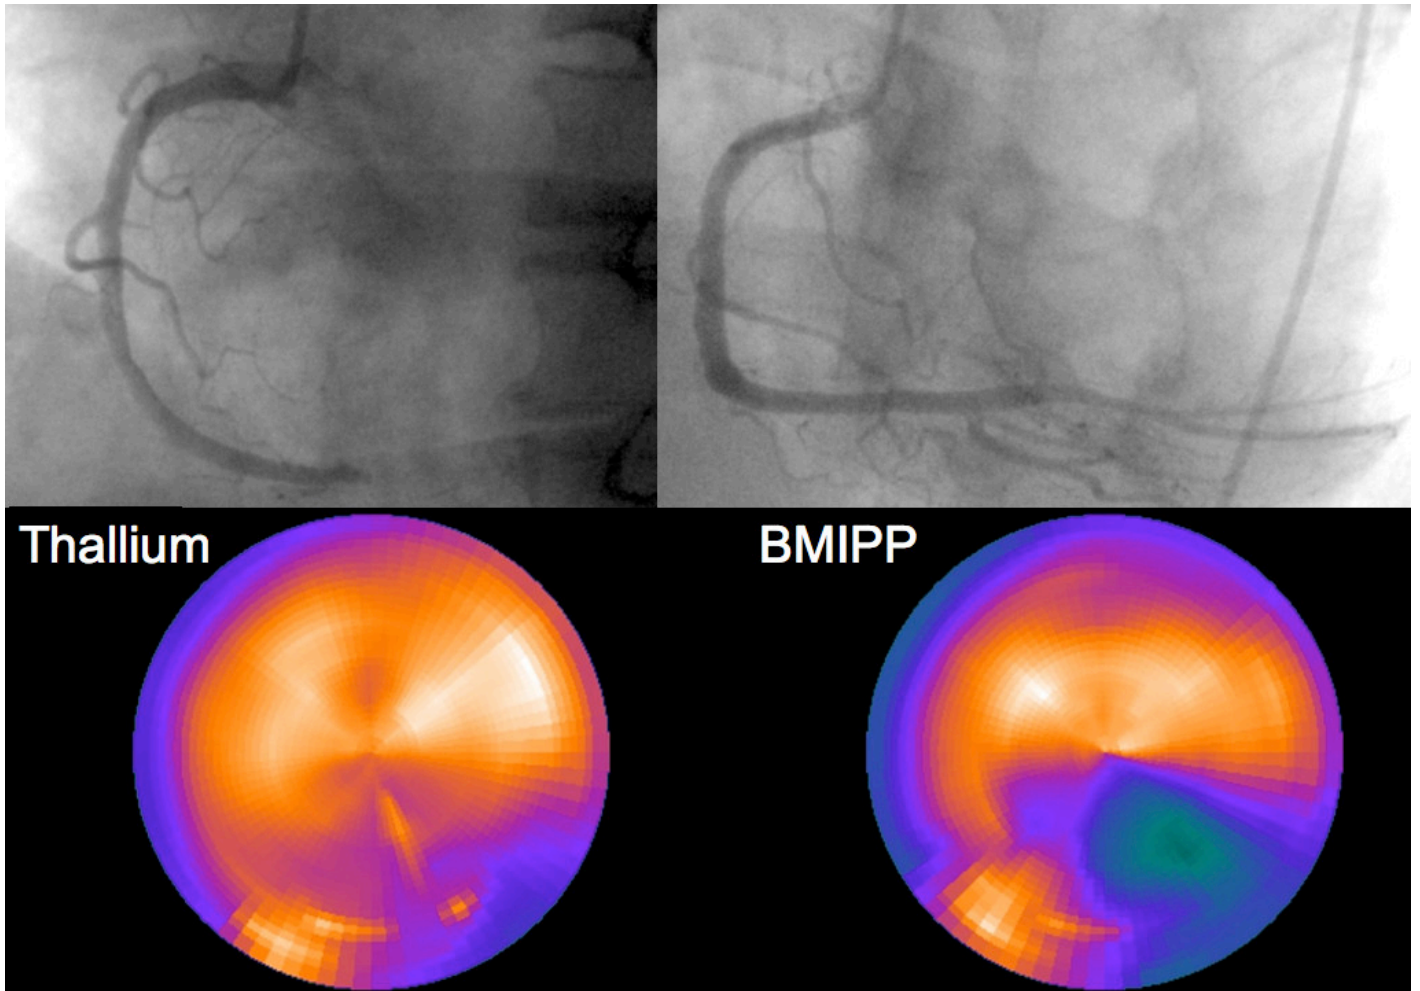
Coronary angiogram (CAG) before and after the completion of reperfusion therapy and dual-loading scintigraph with thallium-201 and iodine-123 beta-methyl-p-iodophenylpentadecanoic acid (BMIPP) before discharge. Upper left panel: CAG obtained prior to reperfusion therapy. The proximal right coronary artery (RCA) is completely occluded. Upper right panel: CAG obtained after completion of reperfusion therapy. Lower panel: Bull's-eye view of a dual-loading scintigraph obtained before discharge, with thallium-201 and iodine-123 BMIPP. The uptake of thallium by the myocardium in the RCA area is good, in stark contrast to the large defect observed on BMIPP imaging.
